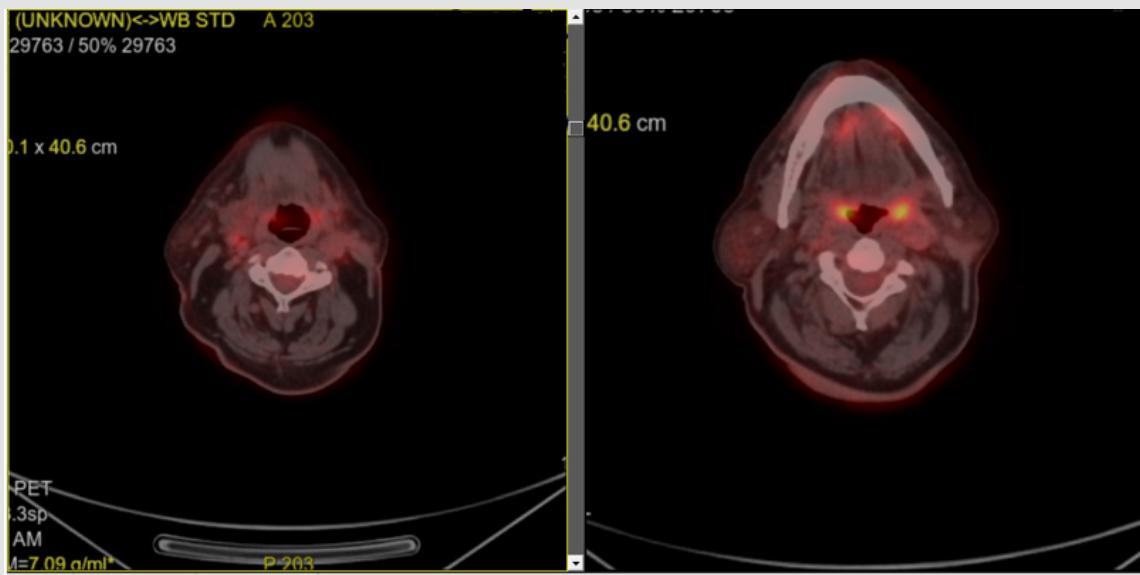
PET-CT head and neck (axial acquisition): Postoperative changes in the left parotid region and status post left selective laterocervical lymphadenectomy (15.01.2025), with no evidence of metabolically active local recurrence. Mild FDG uptake (SUV max 1.65) in left level II-III lymph nodes (up to 13 mm), likely reactive; follow-up recommended. Right laterocervical lymph nodes (up to 8 mm) show no significant metabolic activity (SUV max 0.65). Bilateral tonsillar inflammatory changes noted.
